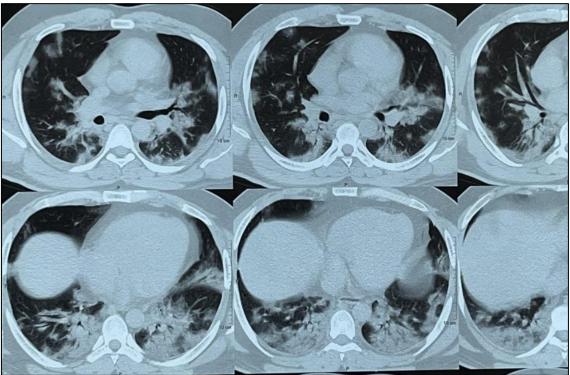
HRCT thorax showing pleural based patchy, multifocal, confluent opacities of consolidation with necrosis with line of demarcation, involving central to peripheral areas of lung parenchyma in both lower lobes
